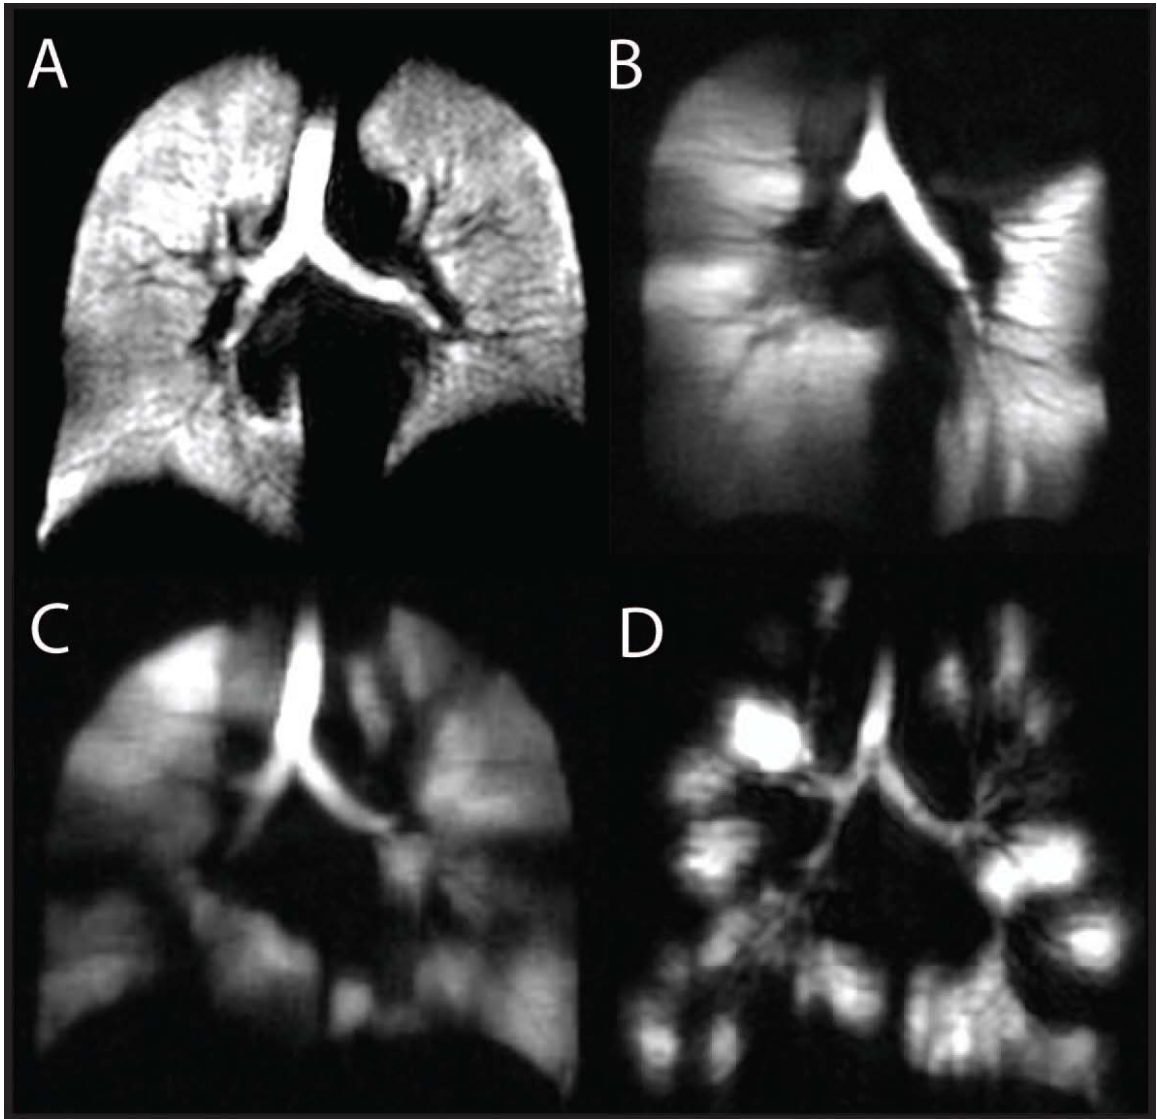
Hyperpolarized ^3He MRI of a healthy volunteer and subjects with different lung diseases
